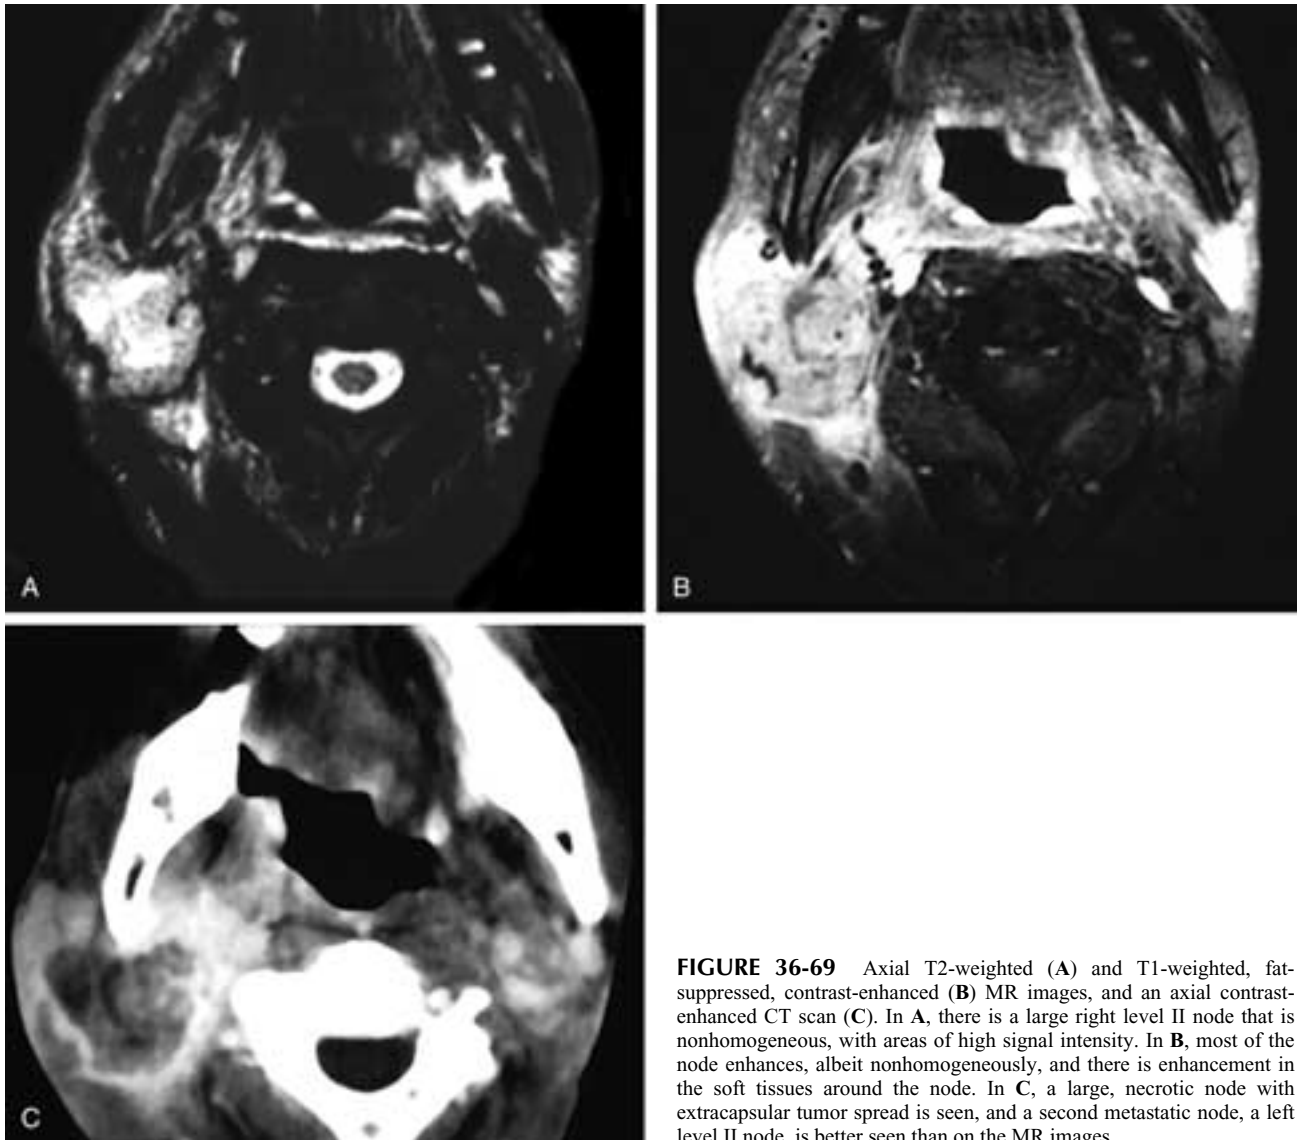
Axial T2-weighted (A) and T1-weighted, fat-suppressed, contrast-enhanced (B) MR images, and an axial contrast-enhanced CT scan (C). In A, there is a large right level II node that is nonhomogeneous, with areas of high signal intensity. In B, most of the node enhances, albeit nonhomogeneously, and there is enhancement in the soft tissues around the node. In C, a large, necrotic node with extracapsular tumor spread is seen, and a second metastatic node, a left level II node, is better seen than on the MR images.
